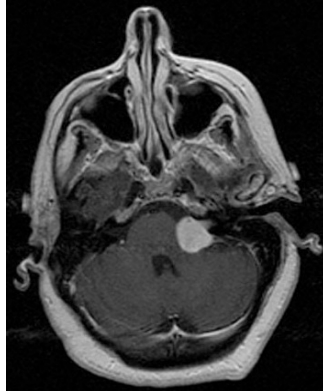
MRI scan representing a left side vestibular schwannoma (RadsWiki, distributed under a CC-BY 3.0 license).
